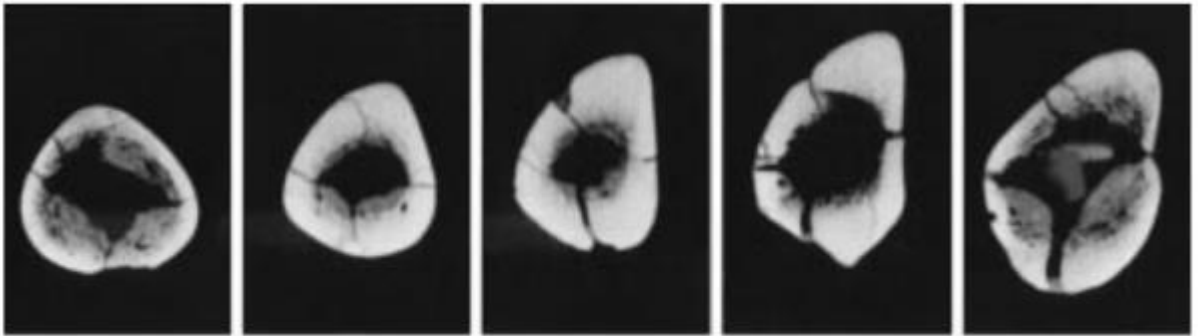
From left to right, CT scans of cross-sections of the Boxgrove tibia at approximately 20%, 35%, 50%, 65% (showing the pilaster), and 80% from the distal end, as taken from Trinkaus *et al.* (1999: 3).
